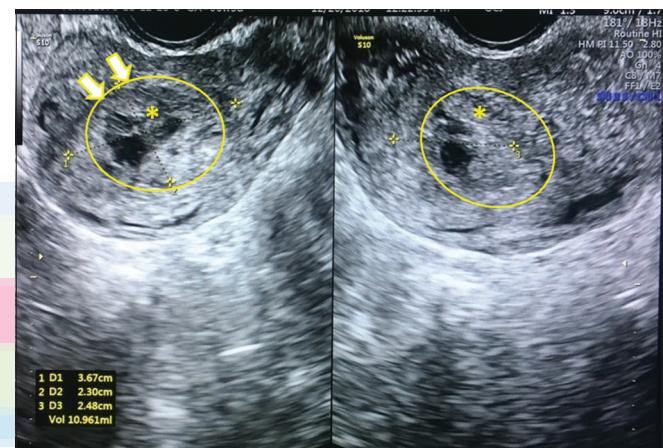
Transvaginal ultrasound showing an ill-defined mass (arrow) measuring 3.67 cm × 2.30 cm × 2.48 cm, extending from the middle to the upper third of the anterior endometrium, with thinning of the myometrium to 0.26 cm over the lesion and presence of lacunae (asterisk)
